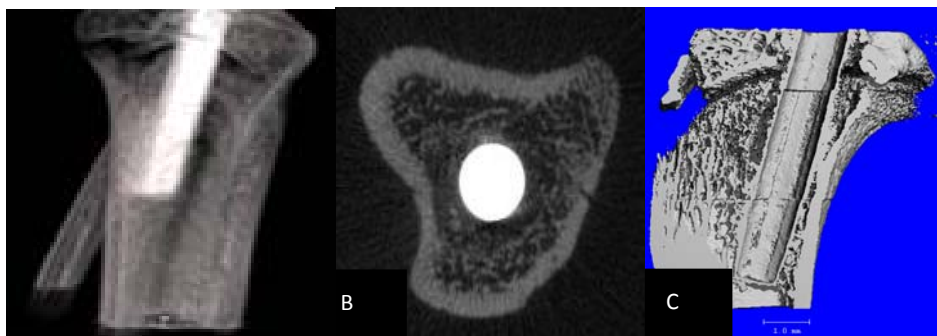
$\mu$ CT: (A) Ti pin implantation at implant/bone interface; (B) cross-section and (C) reconstructed longitudinal section.
